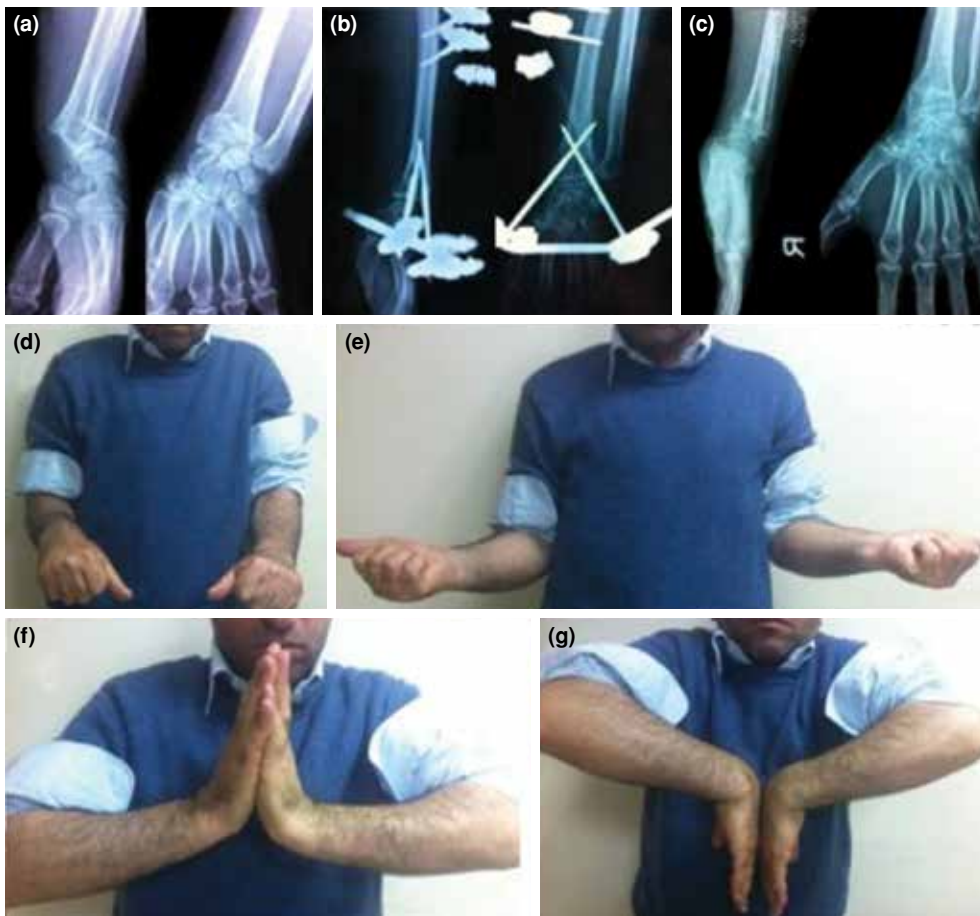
Pre-, early postoperative, and last follow-up radiographic images of wrist of a patient with non-bridging external fixator (a-c). The clinical picture of the patient at final follow-up (d-g).
